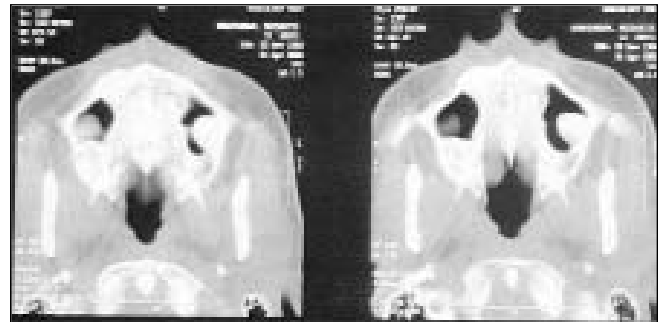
CT-scan of the maxilla showing the radiopaque mass attached to the walls of the maxillary sinus bilaterally
